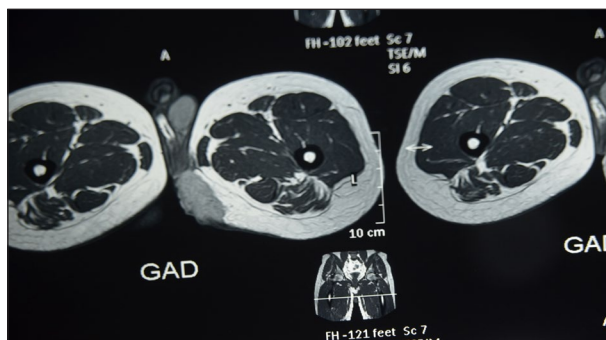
A. MRI showing a mass occupying the left perineal fat tissue and mildly extending to the right side and gluteal region.
